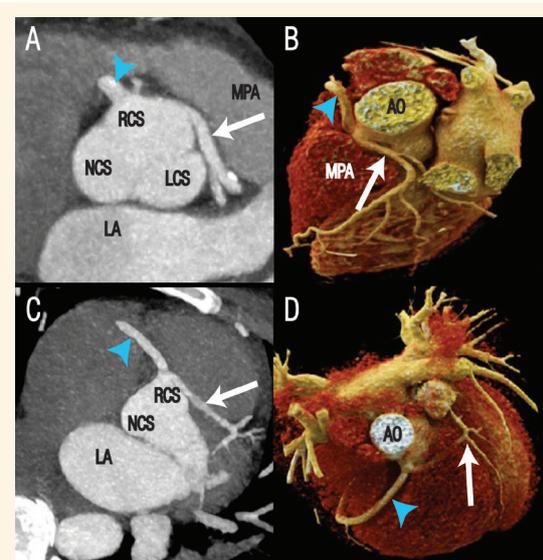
Axial maximal intensity projection via coronary computed tomography angiography imaging (A & C) and three-dimensional volume rendering (B & D) showing (A & B) the left main coronary artery (arrow) arising from the right coronary sinus before it courses to the left between the main pulmonary artery and the aorta and showing (C & D) the left main coronary artery (arrow) arising from the right coronary sinus before it courses to the left through the interventricular septum. The right coronary artery is indicated by the arrowhead.
